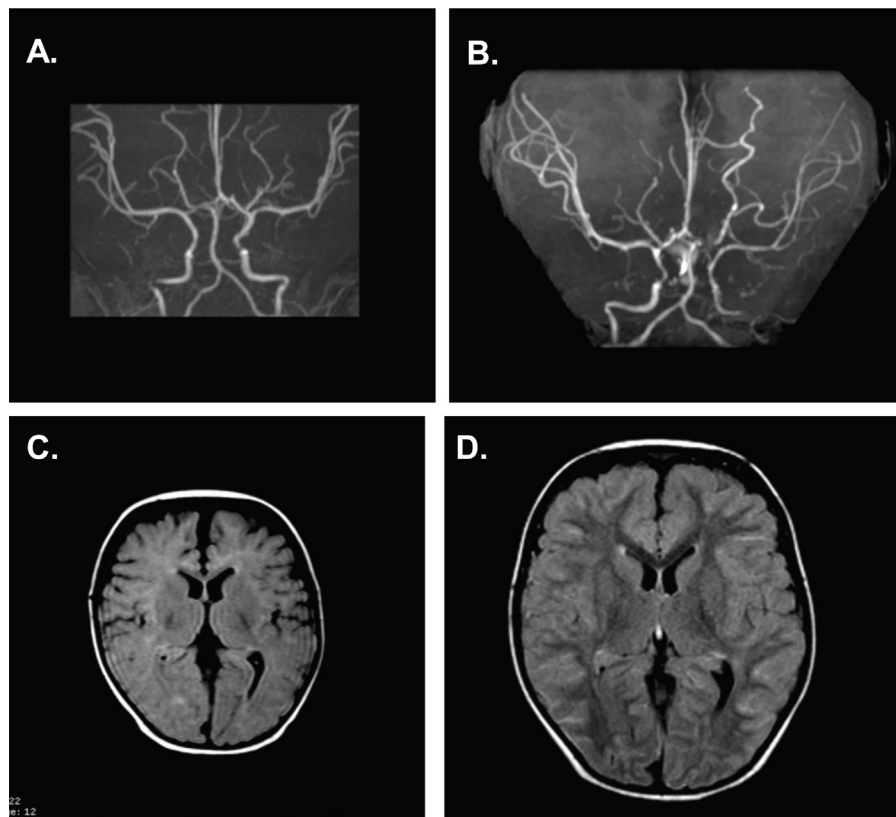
A and B, Magnetic resonance angiography and C and D, axial fluid-attenuated inversion recovery sequences from MRI of a child with ALGS during a 2-year period. A and C, Time zero; B and D, 2 years later. Note the progression in arteriopathy between A and B and the increased fluid-attenuated inversion recovery sulcal hyperintensity ("ivy sign," indicative of slowed cerebral blood flow) between C and D.
